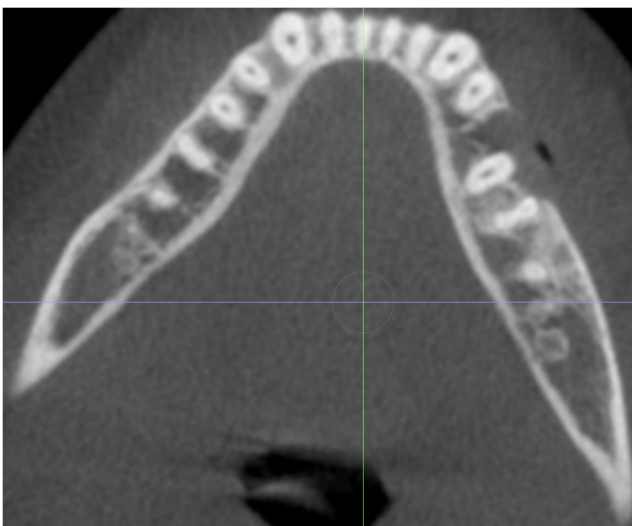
Follow-up CBCT scans at 11 months after marsupialization showing the reduction in the size of the OKC lesion.
